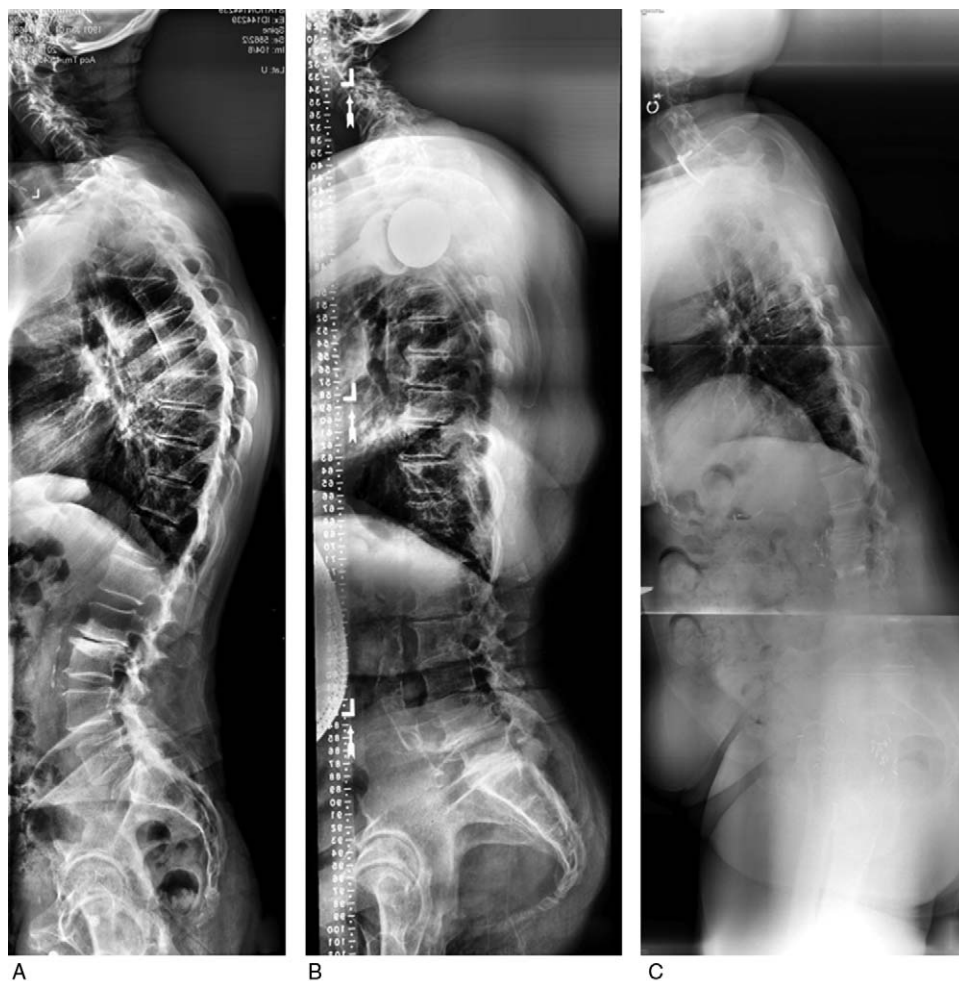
Preoperative lateral radiograph case examples for Not Frail (A), Frail (B), and Severely Frail (C) surgical cervical deformity patients. The mCD-FI scores were 0.20, 0.40, and 0.53, for the Not Frail, Frail, and Severely Frail patients, respectively.
